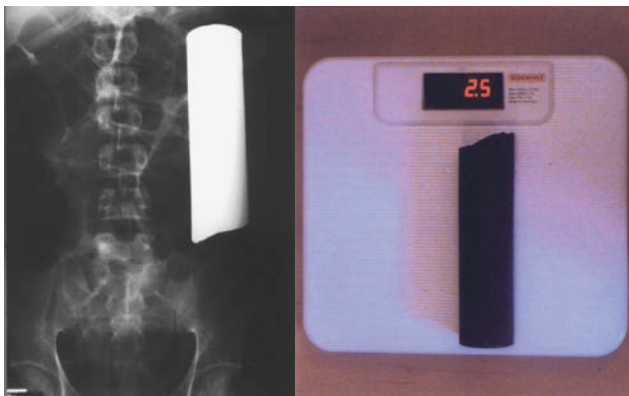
The bar in the sigmoid colon (as seen on a plain abdominal radiograph) and at weigh-in.
